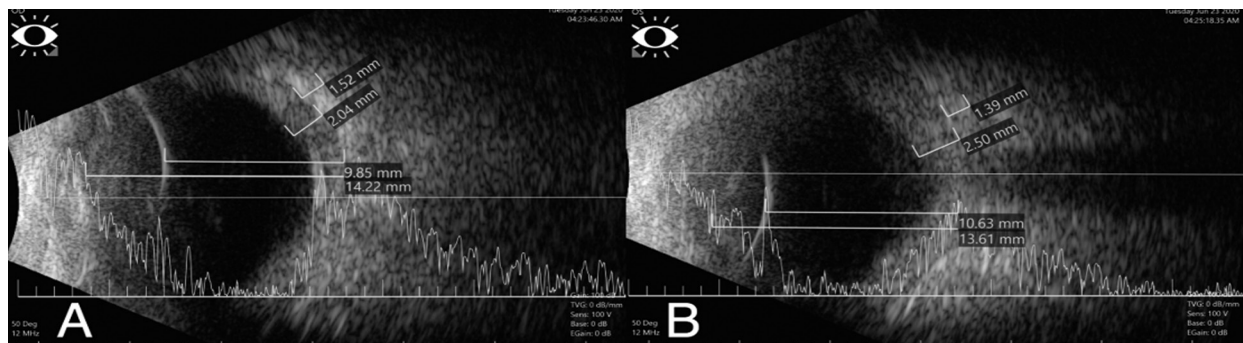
B-scan ocular ultrasound. (A) The right and (B) the left eye both noted to have short posterior segments with clear vitreous as well as thickened sclera and choroid.
